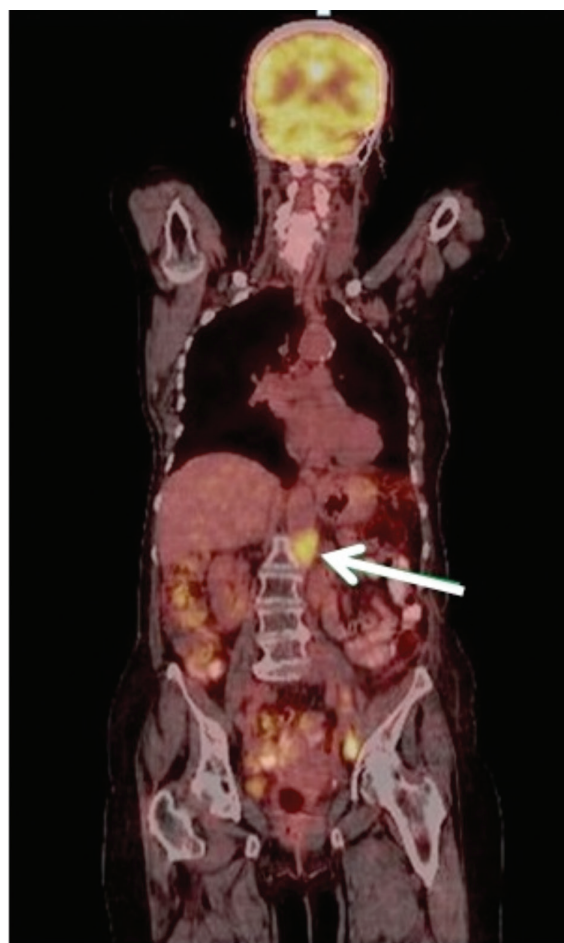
The coronal reconstruction of F-18 fluorodeoxyglucose positron-emission tomography/computed tomography scans shows paraaortic lymphadenopathy (arrow), maximum standardized uptake value: 10.0
